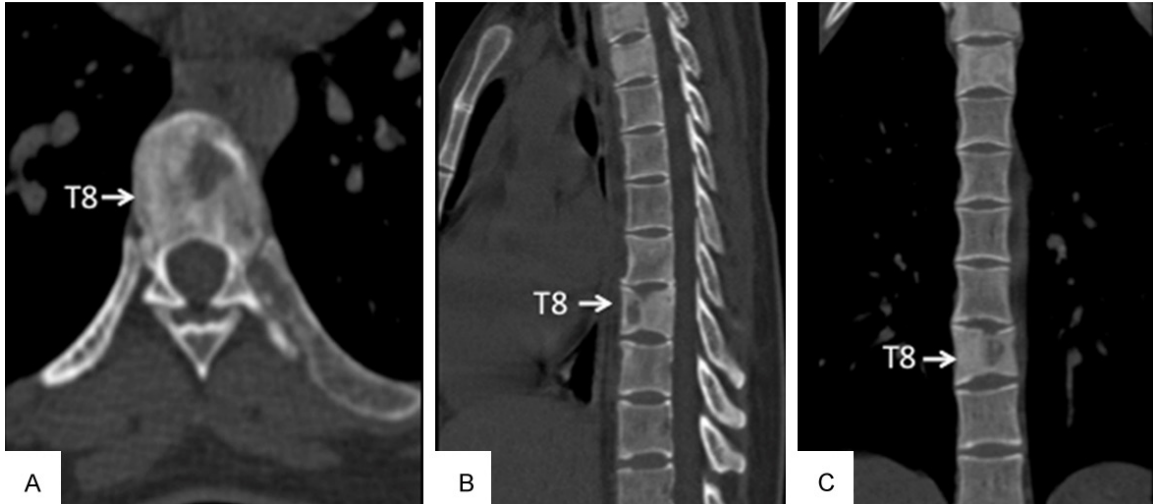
CT of thoracic spine revealed multiple lytic expansile lesions involving several ribs, T2, T3 and T8. (A) Cross section. Sagittal (B) and coronal (C) CT pictures showed obvious collapse in T8.
